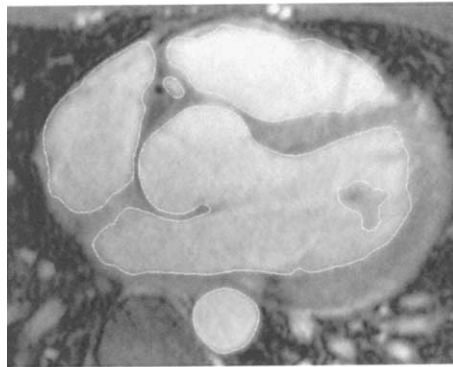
(a) shows a sample MR image from a transversal plane through the heart of a volunteer. The inner cardiac cavities, i.e. the ventricles, the atria, and the aortic root are well defined. Likewise, the descending aorta but also much smaller structures such as the coronary arteries, papillary muscles, and branches of the pulmonary vessels can be distinguished. A segmentation of the image, using only balloons and balloons followed
